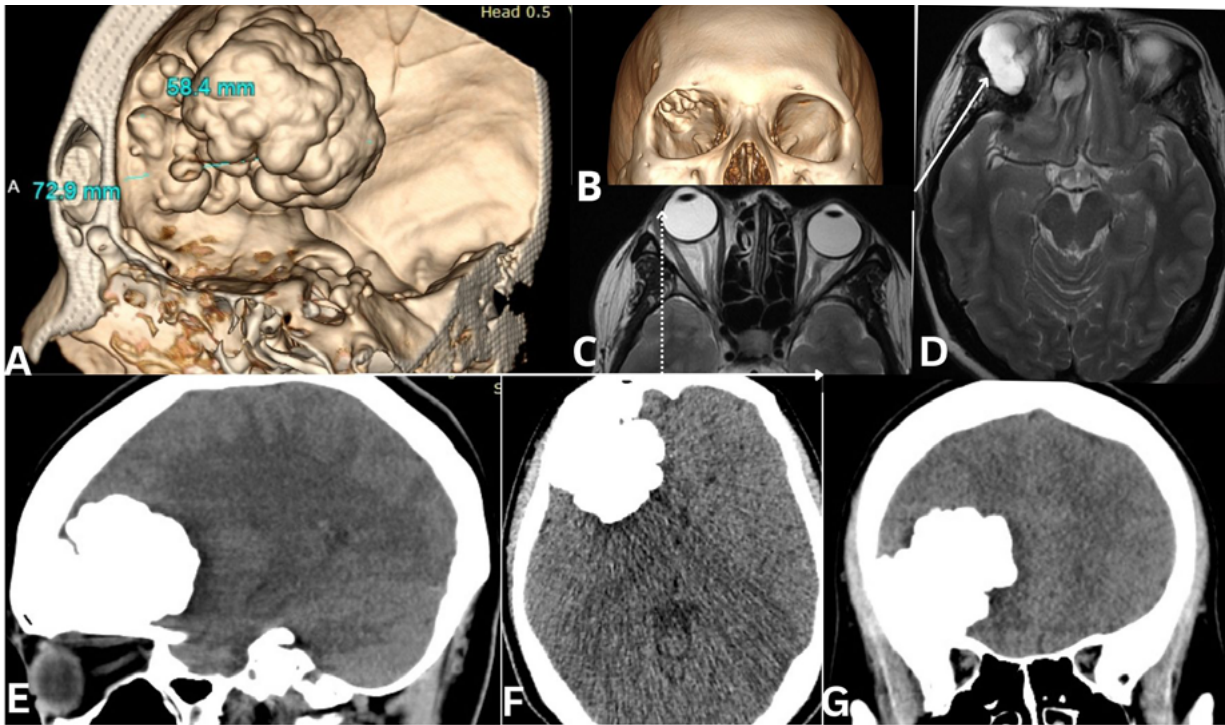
Initial presentation of the patient's osteoma with measurements on CT (Figure 1a); figure 1B demonstrates invasion to the frontal bone; the dotted line on figure 1C demonstrates the proptosis, and an arrow on figure 1 D shows sign of granulomatous inflammation. There are signs of the orbital destruction (Figure 1E, 1F, 1G)
